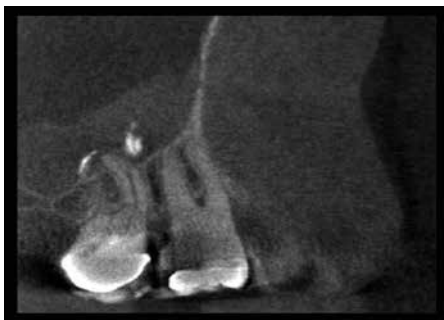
CBCT slice showing extrusion of calcium hydroxide into the maxillary sinus
